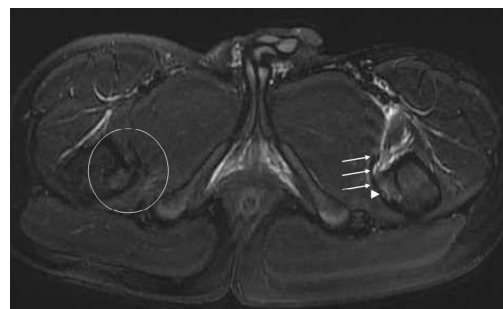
STIR axial hips MRI at level of both lesser trochanters. Both the left lesser trochanter (arrowhead) shows faint high signal intensity but shows no avulsion fracture. The insertion of the iliopsoas tendon (arrow) is the same signal and form as the right side (white circle).
